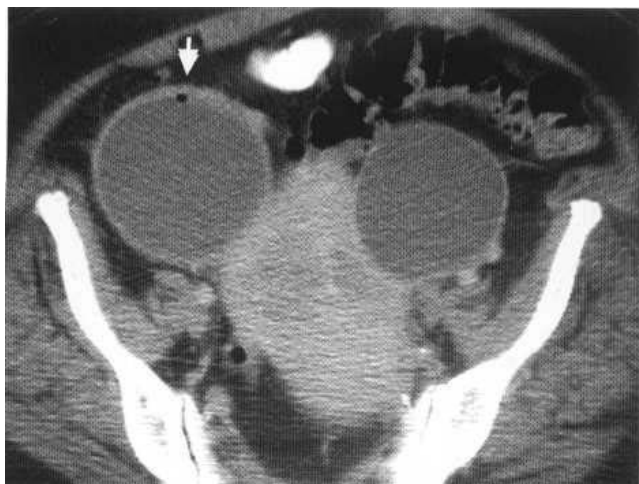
CT. Bilateral cystic adnexal masses. Note the tiny gas bubble (arrow) seen in one of the masses. Laparoscopy confirmed bilateral hydrosalpinges with chronic infection.
